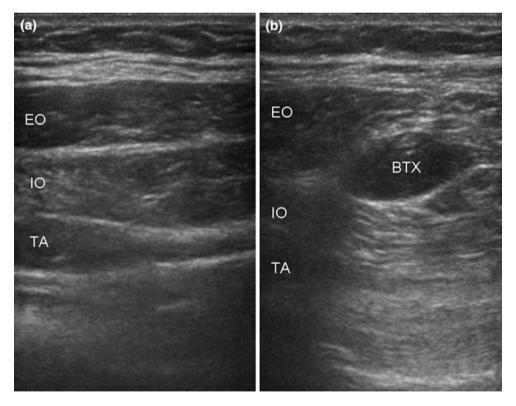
Ultrasound-guided injection of the botulinum toxin into the lateral abdominal wall musculature. a Anatomy of the abdominal wall muscles prior to injection. b Anatomy of the abdominal wall muscles
